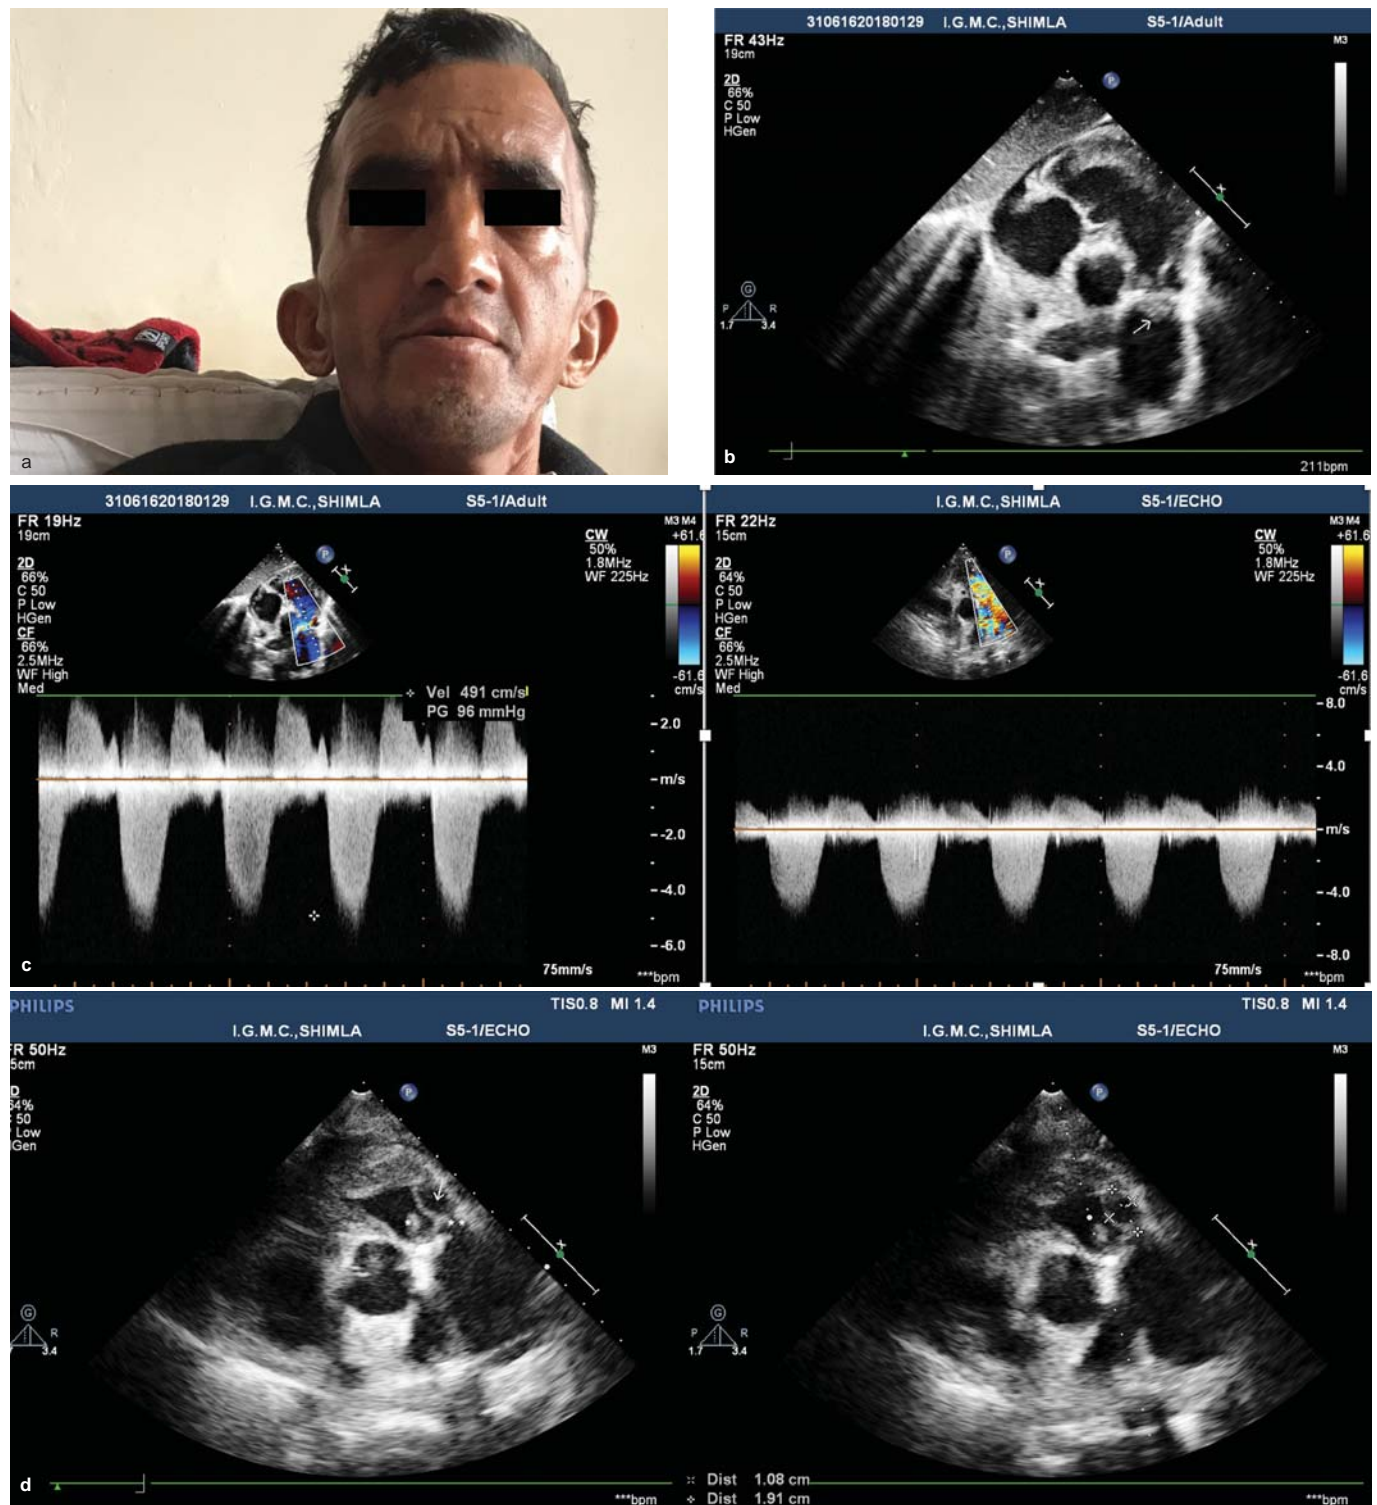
(a) Patient with dysmorphic facies in the form of hypertelorism, low-set and backward rotated ears, small lower jaw and having features of Noonan syndrome; (b) transthoracic echocardiography short-axis view showing evidence of pulmonary valve vegetation; (c) continuous-wave Doppler demonstrates severe pulmonary stenosis (gradient 98 mmHg) with moderate pulmonary regurgitation; (d) transthoracic echocardiography showing evidence of vegetation (marked with*) with evidence of pulmonary annular abscess extending into the right ventricular outflow tract (marked with arrow) of size 1.9 cm×1.0 cm
